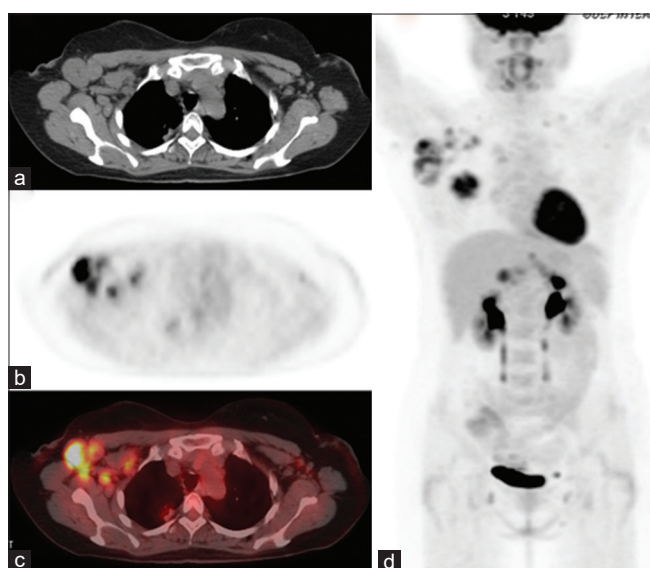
Axial computed tomography, positron emission tomography, fused positron emission tomography/computed tomography, and maximum intensity projection images (a-d) of a patient with locally advanced right breast carcinoma and nodal metastases involving the right axilla as well as the right subpectoral nodal metastatic lesions
